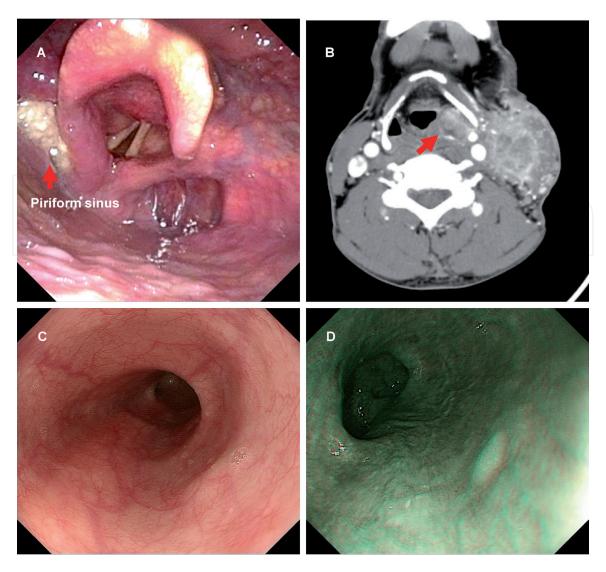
The second primary cancer in hypopharyngeal cancer. (A, B) Hypopharyngeal cancer involving pyriform sinus (red arrow) by endoscopy and CT scan, respectively. (C, D) Second primary esophageal cancer of hypopharyngeal cancer, imaged with (C) white light endoscopy; (D) narrow-band imaging.
